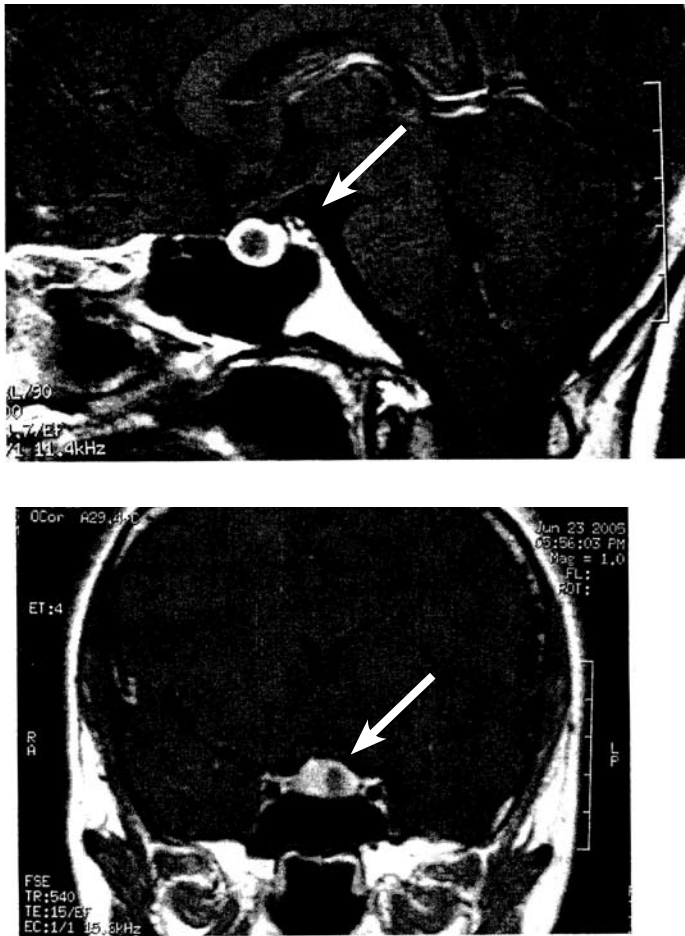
MRI scans depicting this patient's 1x1x1cm microprolactinoma.
